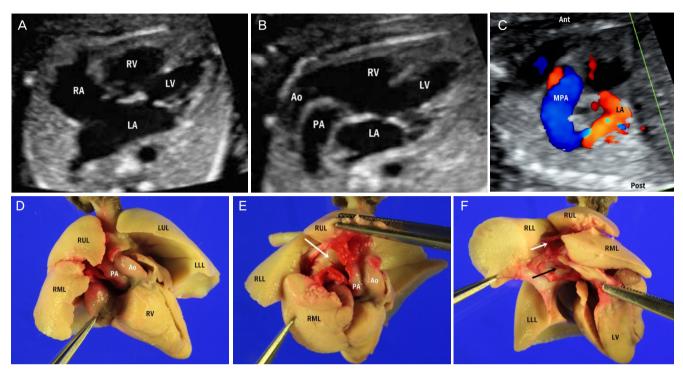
Fetal echocardiographic images obtained at 21.0 weeks of gestation in the current study case demonstrating cardiomegaly with a particularly enlarged left atrium (LA) in the four-chamber view (A), both aorta (Ao) and pulmonary artery (PA) arising from the right ventricle (RV) (B), and an abnormal communication of main pulmonary artery (MPA) and LA with color Doppler in the parasagittal view (C). Postmortem autopsy showing the abnormal root of Ao in front of the pulmonary artery (PA) arising from the RV in the anterior view (D), PA from the RV running between the right upper lobe (RUL) and the right middle lobe (RML) of the lung turning to the left behind the main bronchus in the right superior view (white arrow, opened PA) (E), and PA connecting to the LA in the right posterior view (white arrow, opened PA; black arrow, opened LA) (F). The inside of LA was dyed by red ink flowing through the PA. RA, right atrium; LV, left ventricle; Ant, anterior; Post, posterior; LUL, left upper lobe; LLL, left lower lobe; RLL, right lower lobe.
